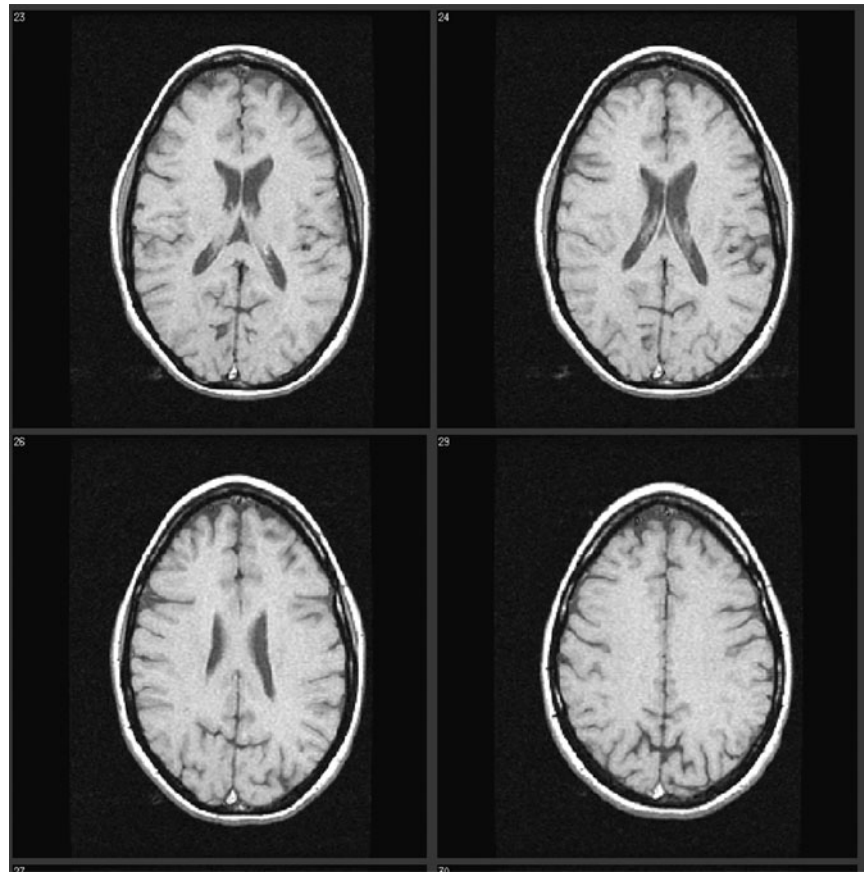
Brain atrophy appears to be absent in the FLAIR images of an age- and sex-matched healthy volunteer who corresponds with the patient in Figure 1.
